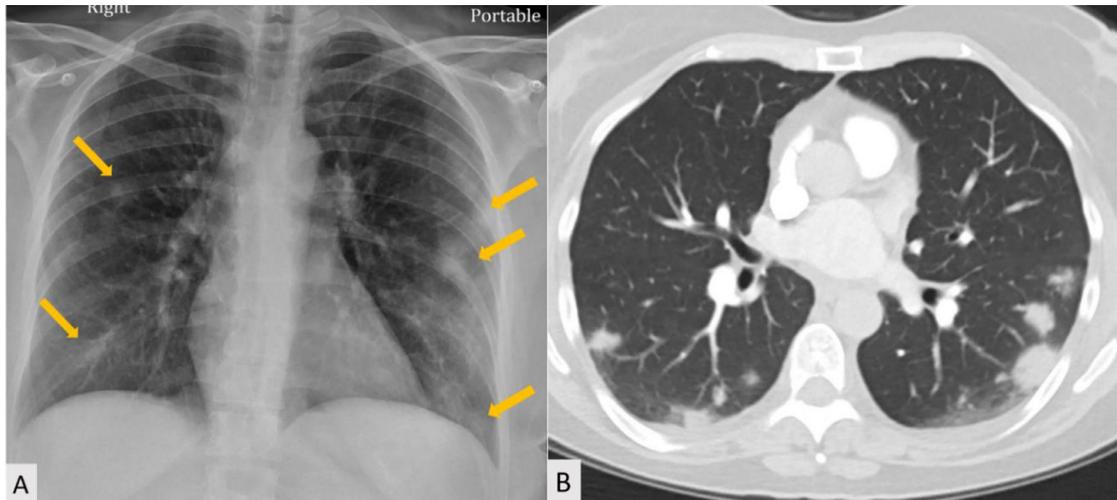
Patient (A) chest radiography and (B) axial CT demonstrating the classic rounded morphology (arrows) of pulmonary opacities associated with COVID-19 pneumonia.
